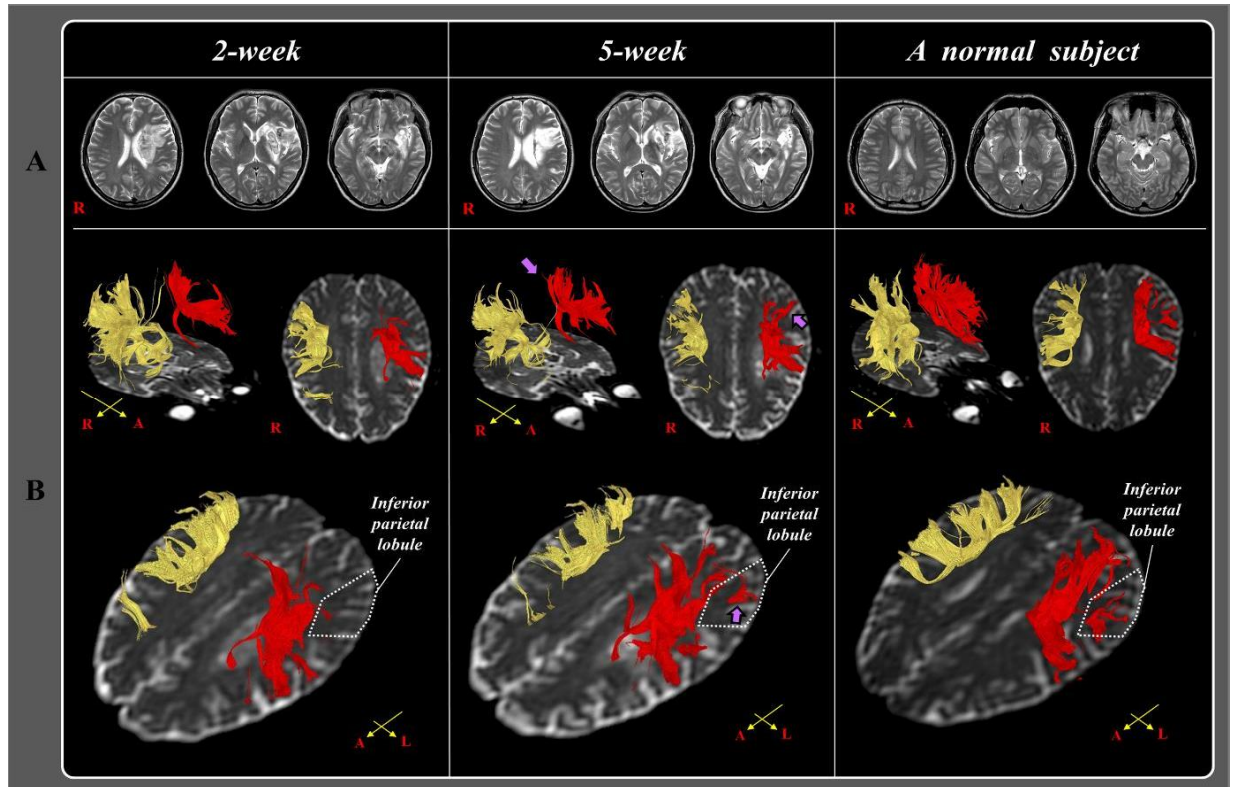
T2-weighted brain MR images at two weeks and five weeks after onset show leukomalactic lesions in the left middle cerebral artery territory. B: Results of diffusion tensor tractography (DTT). The left superior longitudinal fasciculus (SLF) shows injury in the inferior parietal lobule (IPL) area on 2-week DTT. By contrast, the injured left SLF extends to the left IPL area on 5-week DTT (purple arrows)
